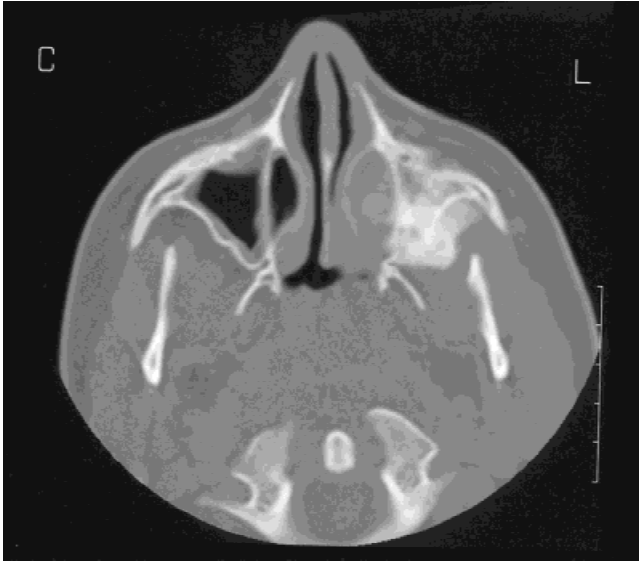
Contrast-enhanced computed tomography (CT scan) of the maxilla of Case 1, showing tumor mass with focal bone destruction of the left maxilla.
